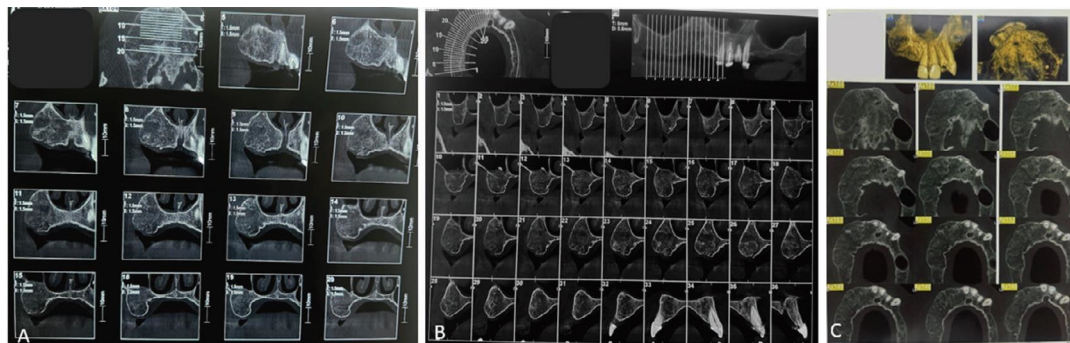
Cone-beam computed tomography (CBCT) images of the right maxilla. (A) The coronal view demonstrates the expansion of the lesion into the right maxillary sinus, elevating its floor. (B) The cross-sectional view shows the significant buccal and palatal expansion of the alveolar process. (C) The axial view displays the ill-defined borders of the lesion and its characteristic ground-glass radiopacity, which has replaced the normal trabecular bone pattern.
